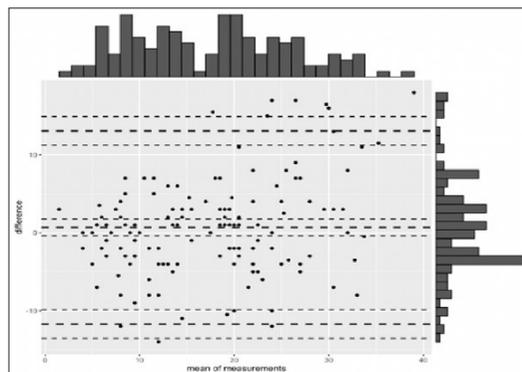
Bland-Altman plot for agreement between CT syntax score and invasive syntax score.
